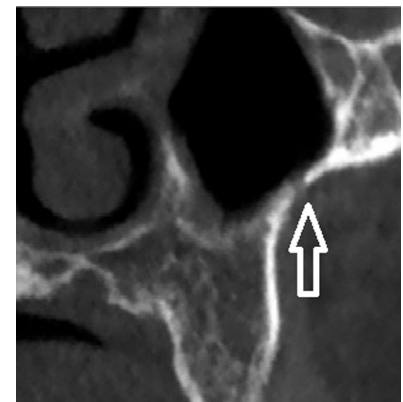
Transverse view of the CBCT scan of a sinus showing the posterior superior alveolar artery inside the bone (type II).
